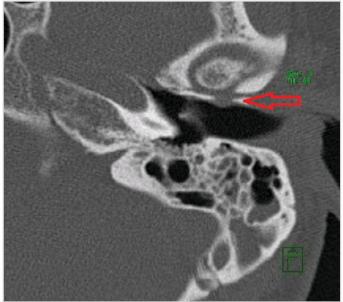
CT image of the bone defect between the anterior wall of EAC and glenoid cavity
